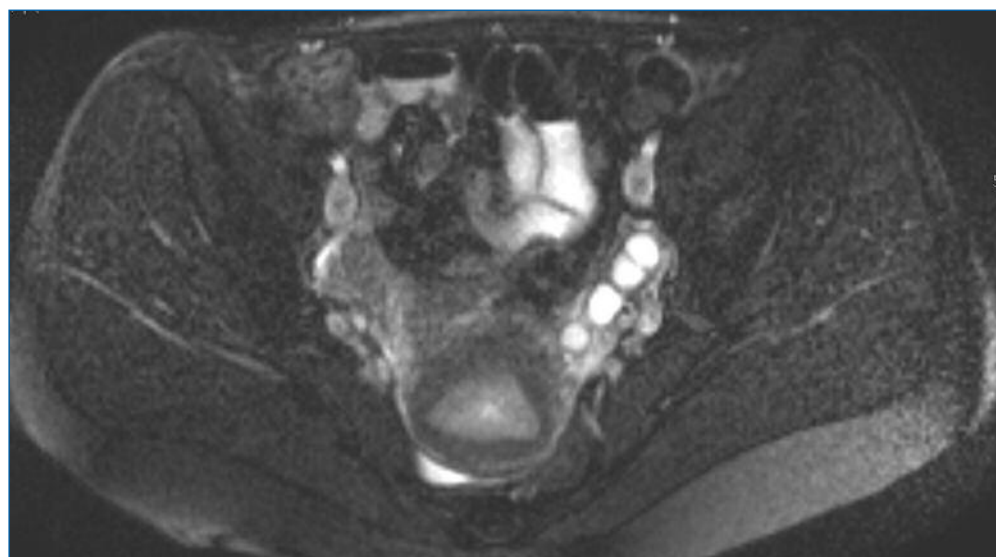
T2 Fat Sat axial MRI: left para-uterine varicocele.
